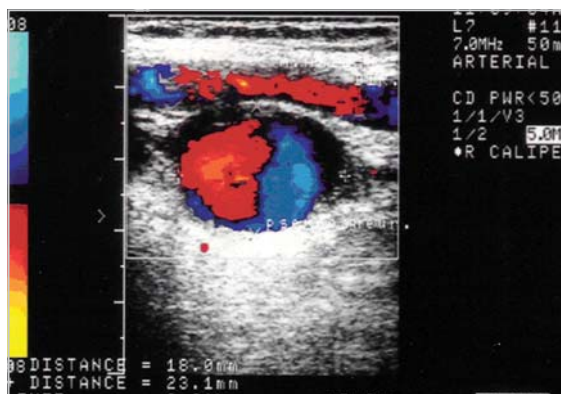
Photography of colour Doppler result showing right axillary artery pseudoaneurysm
